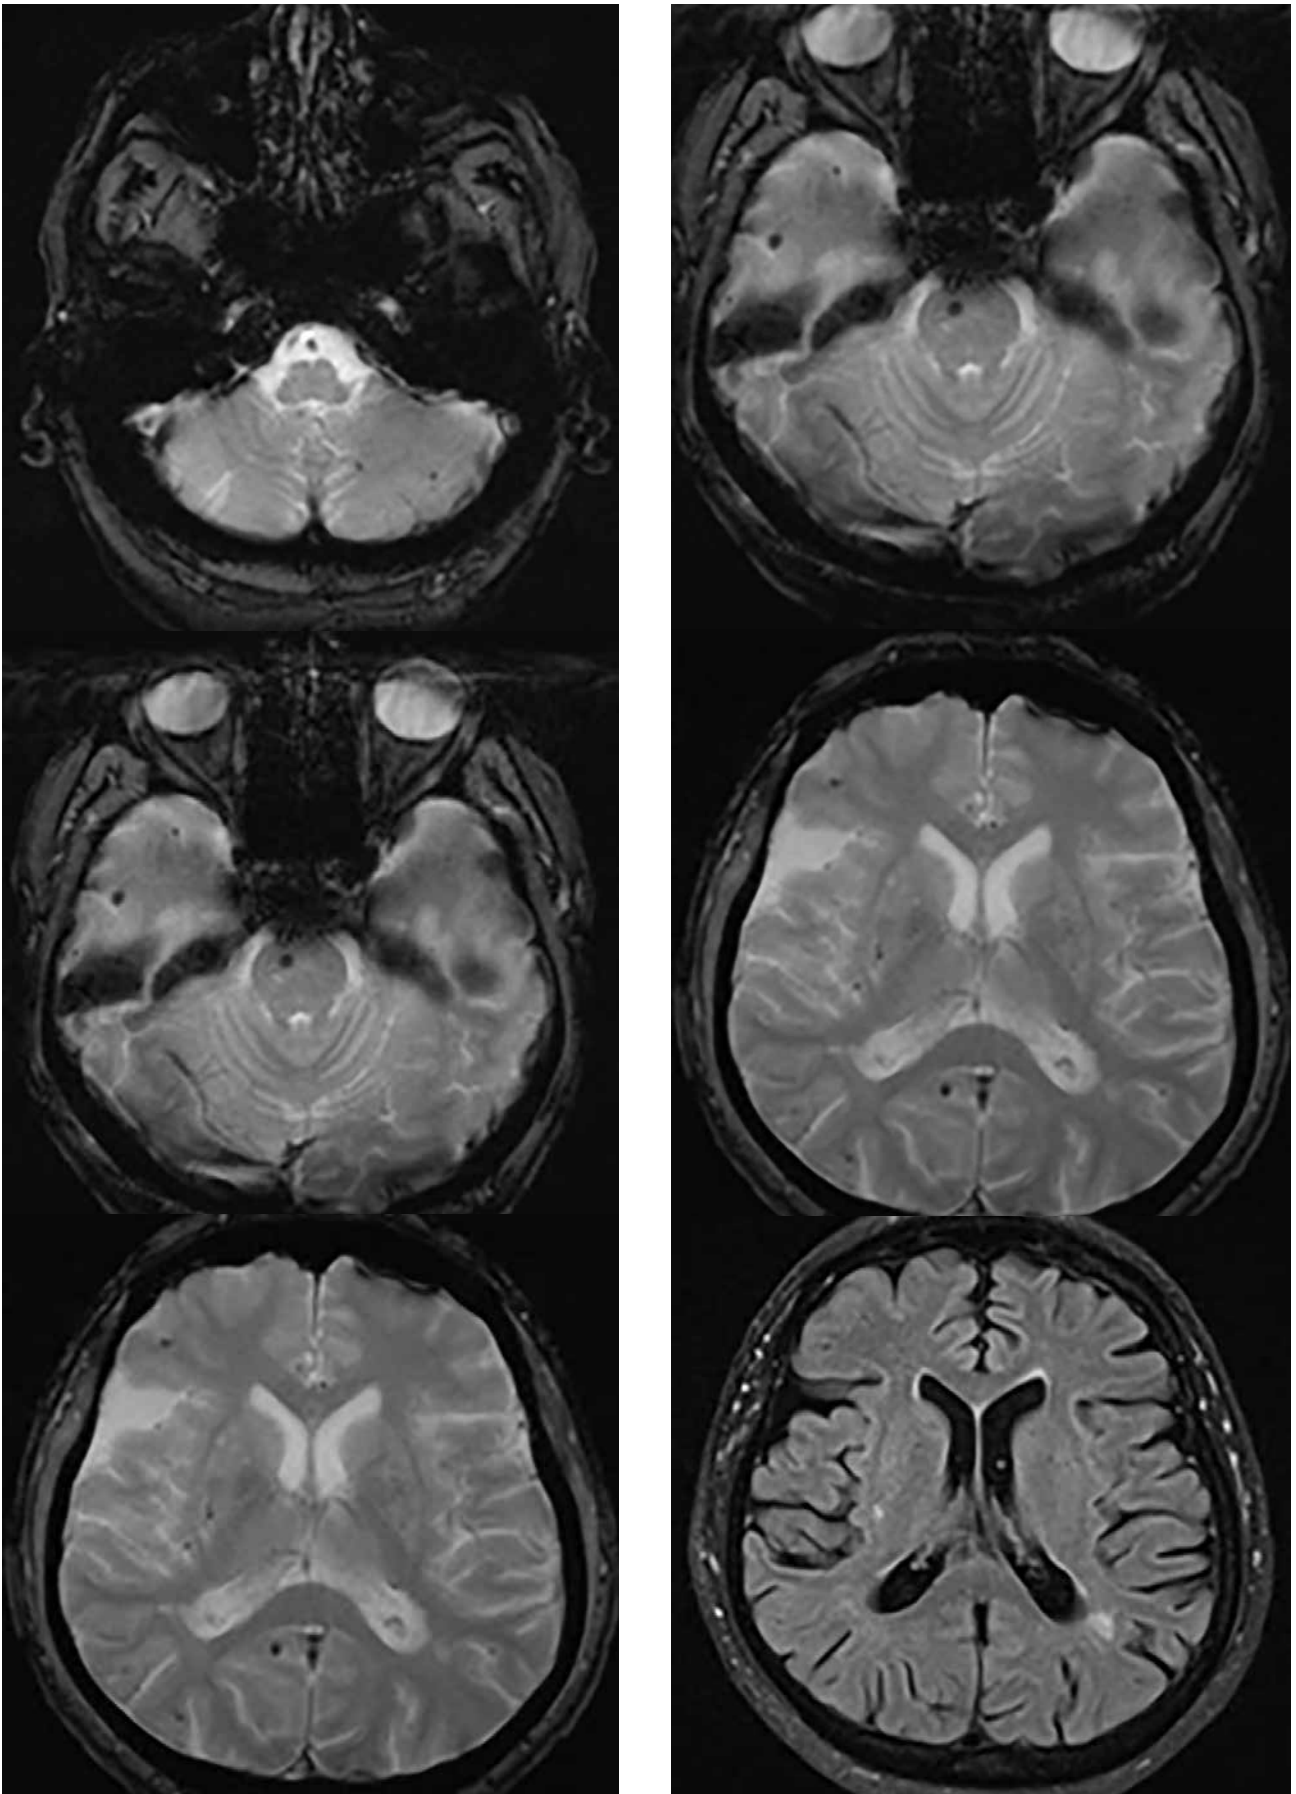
Cerebral amyloid angiopathy and encephalopathy, MRI (a - e T2W fl2d hemo axial; f - T2W/FLAIR axial).
